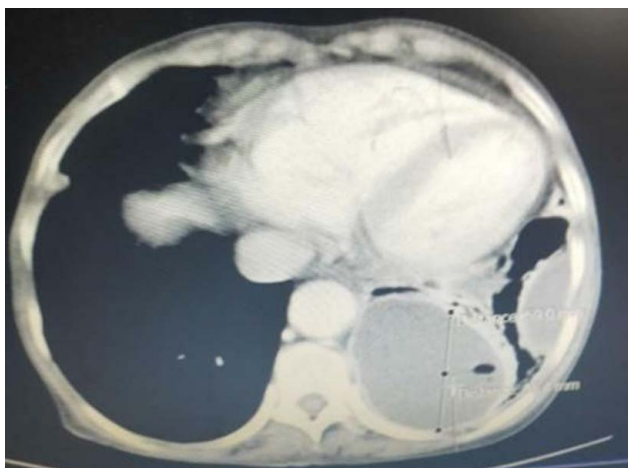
Contrast-enhanced chest CT revealing loculated fluid collections with variable sized locules largest measuring (6 × 7 cm) in the left chest cavity. CT, computed tomography.
